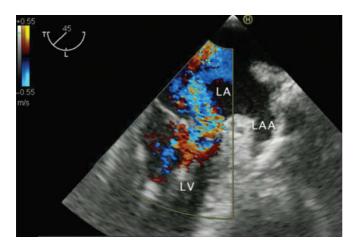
Mid-esophageal 2-chamber view using transesophageal echocardiography. Severe mitral regurgitation and eccentric regurgitant jet blowing rightward within the left atrium is seen. LA = left atrium; LV = left ventricle; LAA = left atrial appendage. From Figure 1C of Kashiura M, Tateishi K, Yokoyama T, et al. Unilateral cardiogenic pulmonary edema associated with acute mitral regurgitation. *Acute Med Surg.* 2017;4(1):119–122. doi:10.1002/ams2.234.
